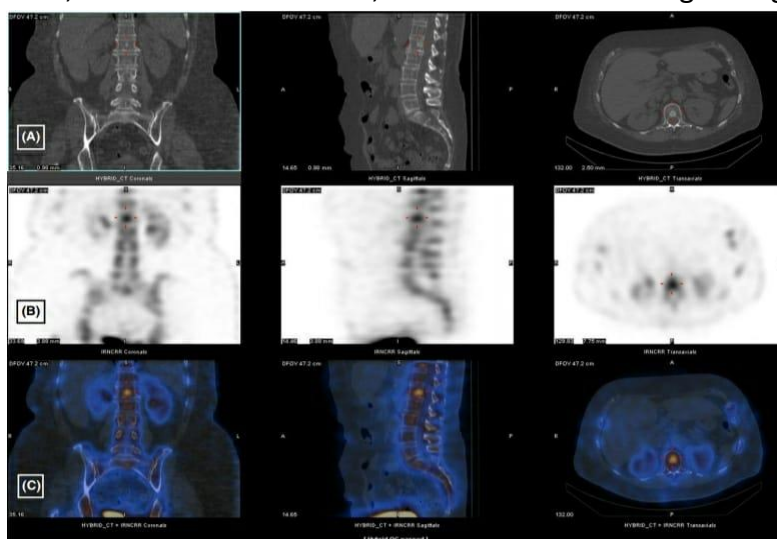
3 SPECT/CT images of the same patient revealing sclerosis in the vertebral body of L1 on CT images (A) which correspond to an area of increased focal uptake on SPECT (B) and fused SPECT/CT (C) most consistent with metastatic disease. This lesion was not apparent on WBBS. Additionally, degenerative changes (which affect intervertebral discs or facet joints) and metastatic disease (which primarily affect the vertebral body) are both common pathologies occurring in the lumbar region and thus require anatomic information for an accurate diagnosis. These images clearly highlight the significance of hybrid imaging in evaluating vertebral metastatic involvement and increasing diagnostic confidence. SPECT, single-photon emission computed tomography; WBBS, whole body bone scan. Image courtesy of Regional Imaging, a member of I-MED Network Radiology, Wagga Wagga, NSW
